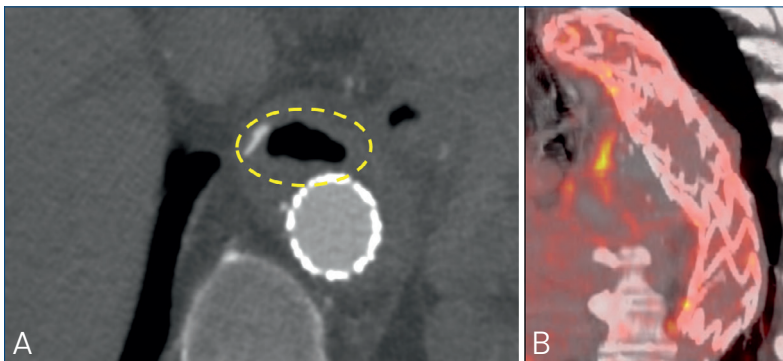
● Radiological signs of infection of an endograft. A) CT scan of thoracic endograft with a large gas bubble; B) PET scan with intense gas capitation of the thoracic stent-graft.
